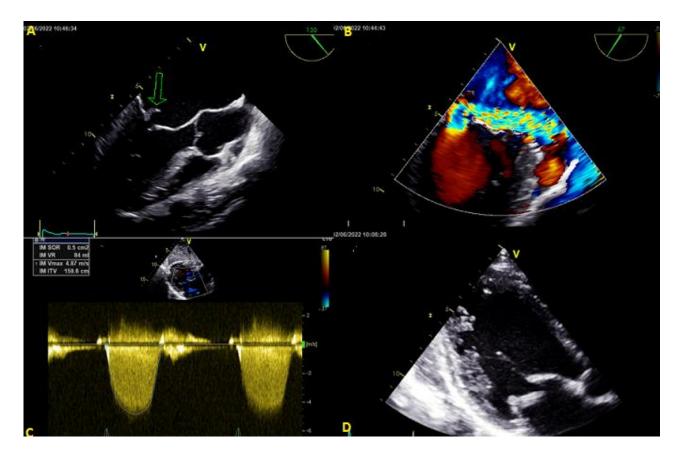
(A) transoesophageal echocardiography showing a P3 mitral valve prolapse; (B) mitral regurgitation color doppler flow; (C) continuous wave doppler through the mitral valve showing a severe mitral regurgitation effective regurgitation orifice: 50mm² regurgitation volume: 84ml; (D)transthoracic echocardiography apical three chambers view showing the mitral prolapse
